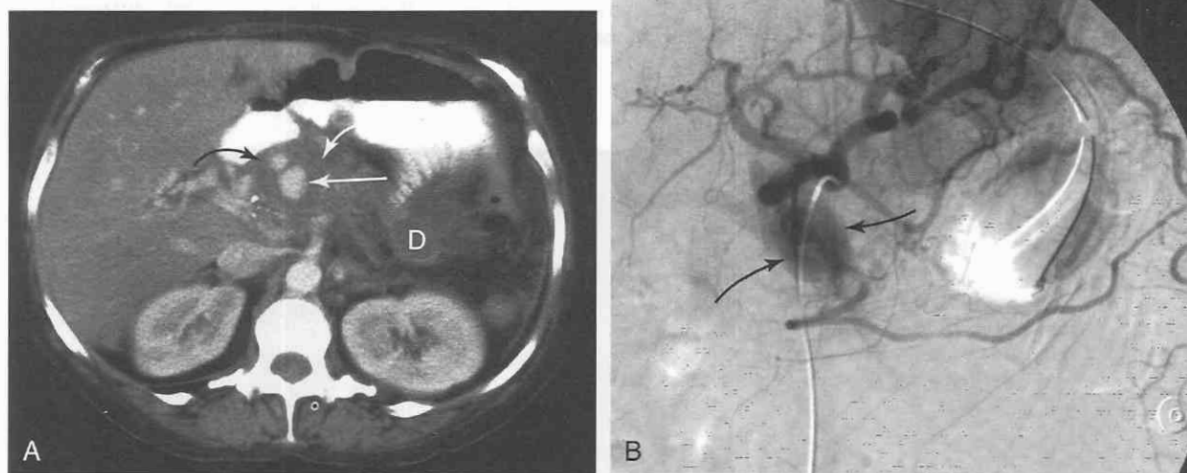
A, Axial CT scan shows enhancing focus in the head of the pancreas (*straight arrow*) posterior to the portal vein coursing toward the porta hepatis region. It is located in an inflammatory mass (*curved arrows*). Note the severely dilated pancreatic duct (D). B, Traditional angiogram shows “pooling” of contrast material in a pseudoaneurysm (*arrows*).
